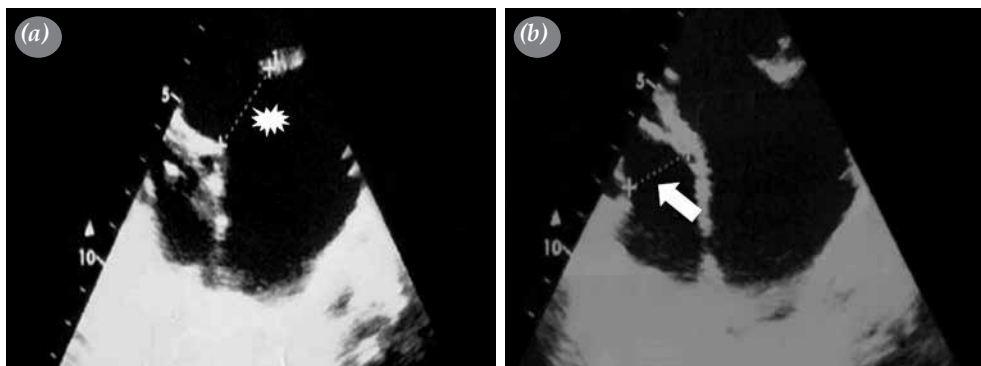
Preoperative transthoracic echocardiography showing significant dilatation of systemic ventricle with an increased diameter of tricuspid annulus. (a) Tricuspid-systemic valve annulus (Asterisk). (b) Mitral-right atrioventricular valve annulus (Arrow).
